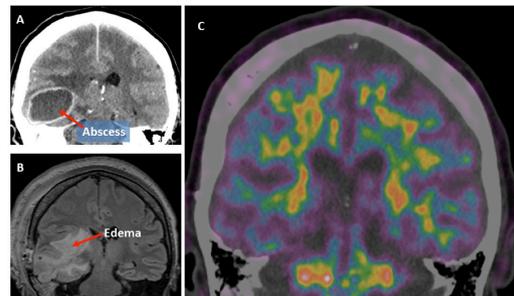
Patient, 60 y, with a large abscess in the right temporal lobe as seen on CT (A). MRI two days after pus evacuation shows persistent edema (B). 31F-Flutemetamol PET seven months later shows no accumulation of beta-amyloid locally or globally, but rather a decreased signal in white matter in the region of the previous abscess (C).
